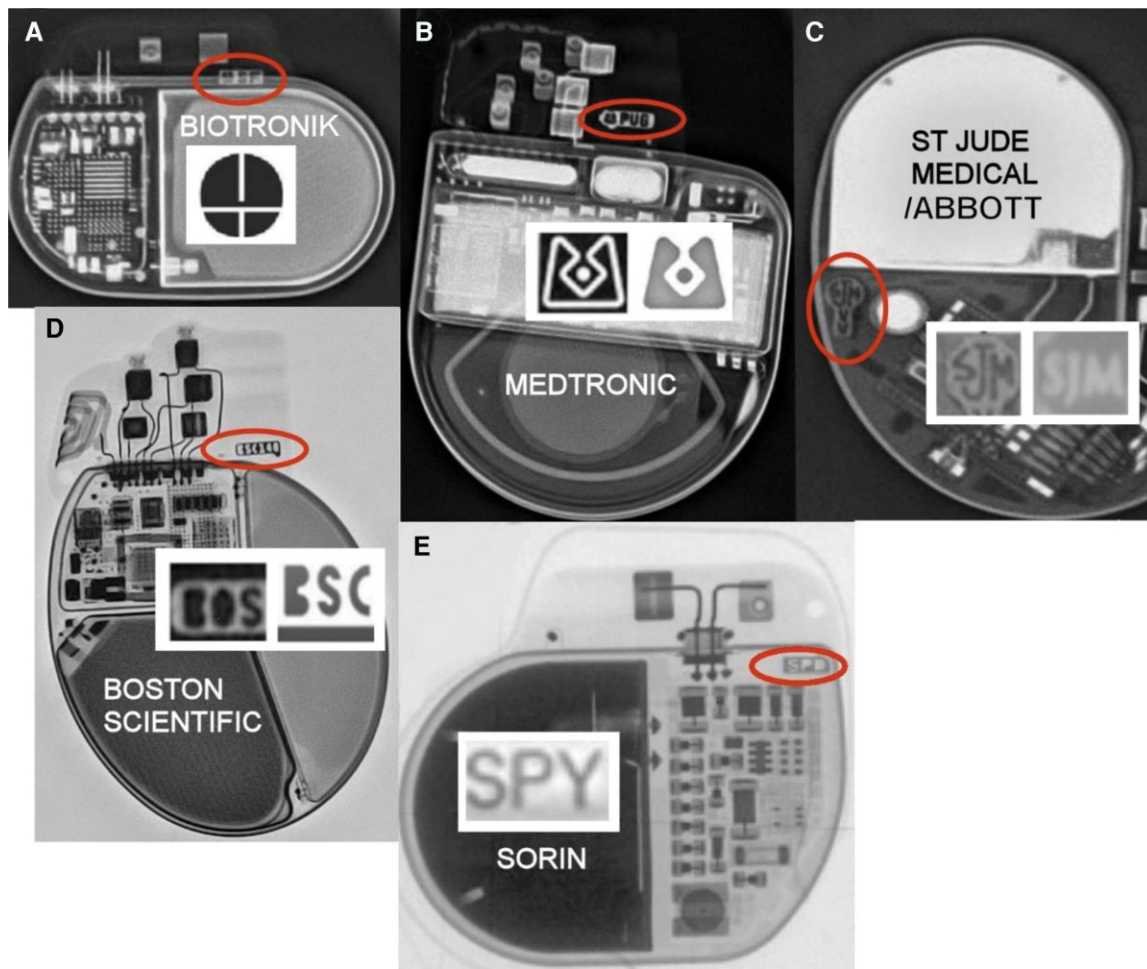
Identification of the CIED manufacturer based on X-ray markers: X-ray opaque symbols of individual manufacturers marked with a red ellipse and enlarged on the background of the CIED silhouette. (A) CIED manufactured by Biotronik, (B) by Medtronic, (C) by St Jude Medical/Abbott, (D) by Boston Scientific, and (E) by Ela/Sorin.
